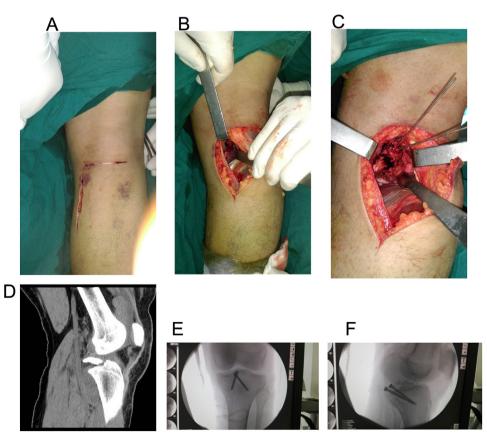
(A–F): (A) Lines of incision as drawn on posterior aspect of the knee. (B) The plane developed between the medial gastrocnemius head and semimebranosus. (C) Temporary fixation by 2 k-wires before use of cannulated screws. (D) Preoperative C-T cuts. (E–F) Postoperative radiographs.
